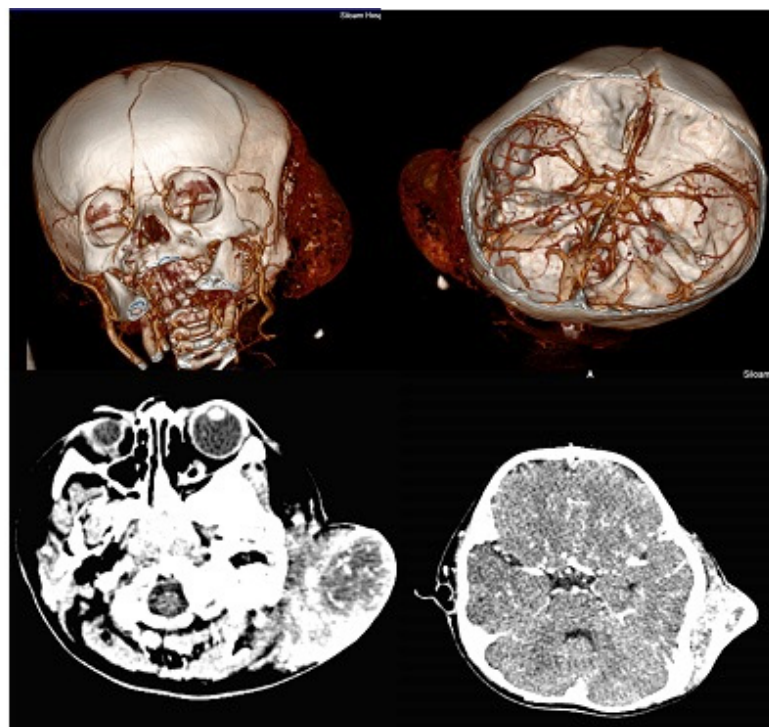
CT scan with contrast and 3D reconstruction.
